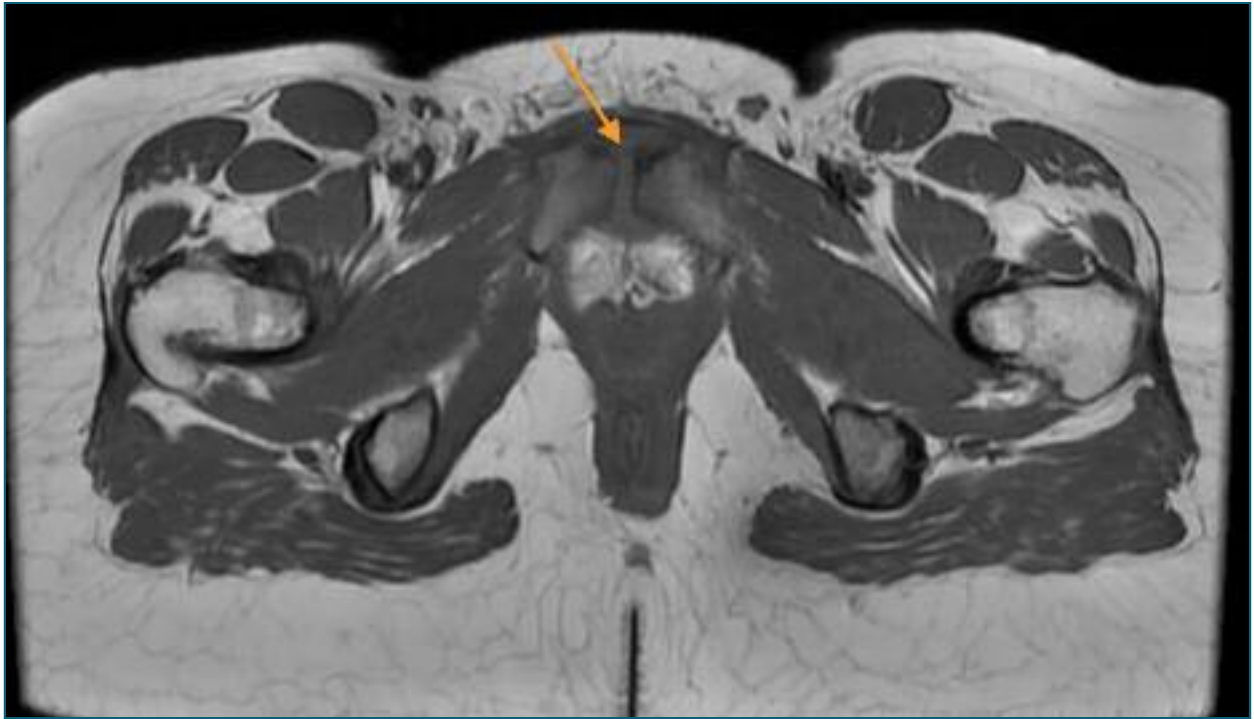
Pelvic MRI (axial plane) – MRI showing hyperintense T2 signal and cortical irregularities on the articular surface and densifications of the soft tissues.
